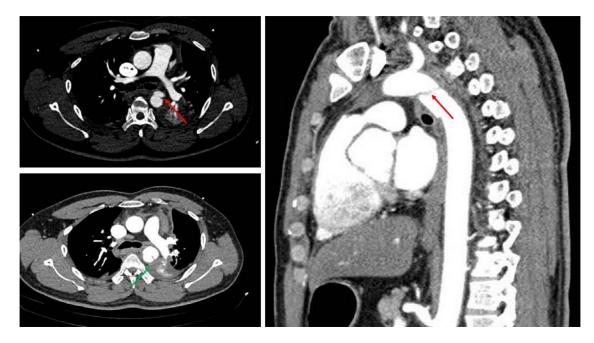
Computed tomographic angiography revealing the contour disruption, an intimal flap, luminal filling defects of descending thoracic aorta (red arrow) and periaortic hematoma formation (green arrow).
